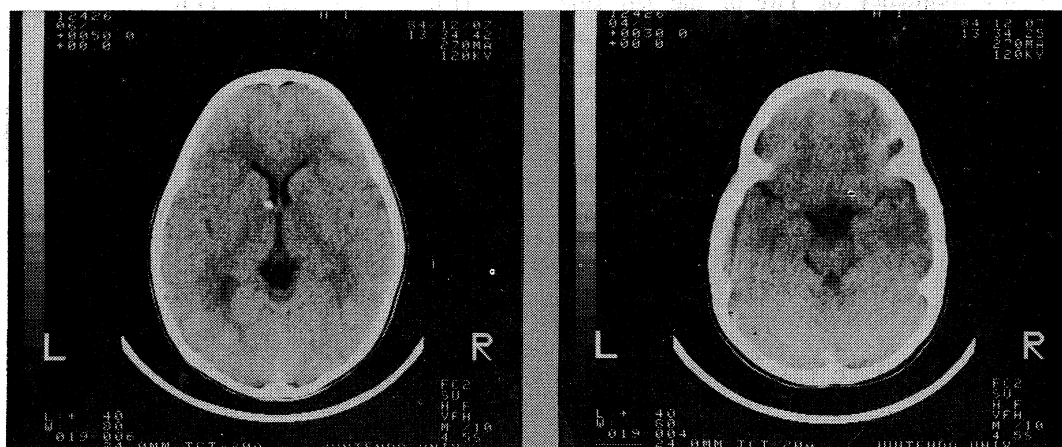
CT scans of Case T.E. showing a tubercle located in the same region as Case R.K.
